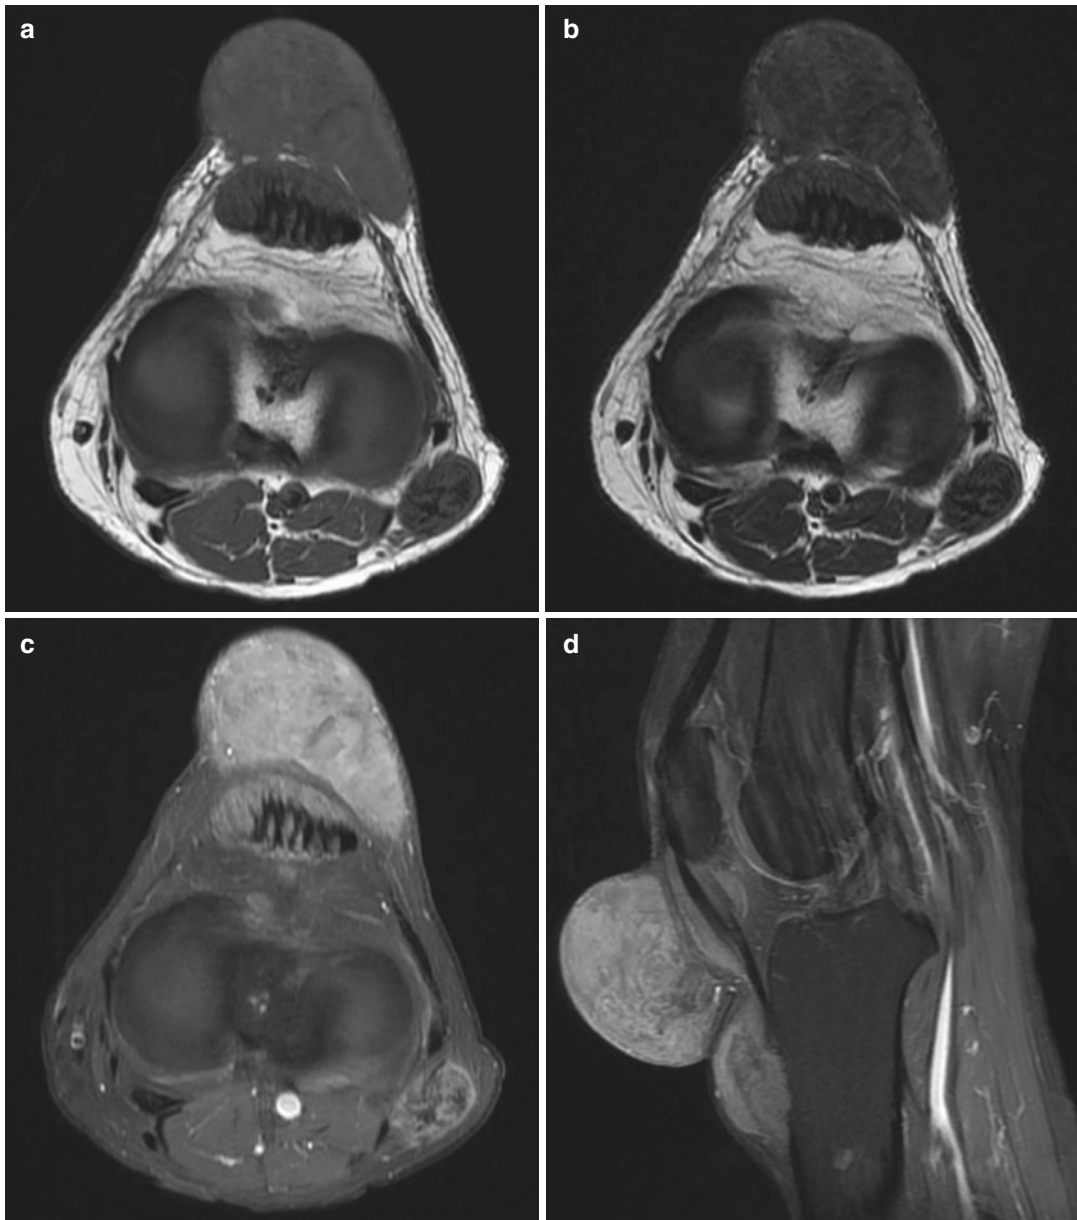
Xanthoma. MR images (a–c) show diffuse thickening of the patellar ligament and distal biceps femoris tendon. The affected tendons have a speckled appearance, with an inner low signal intensity on axial T1WI (a)
